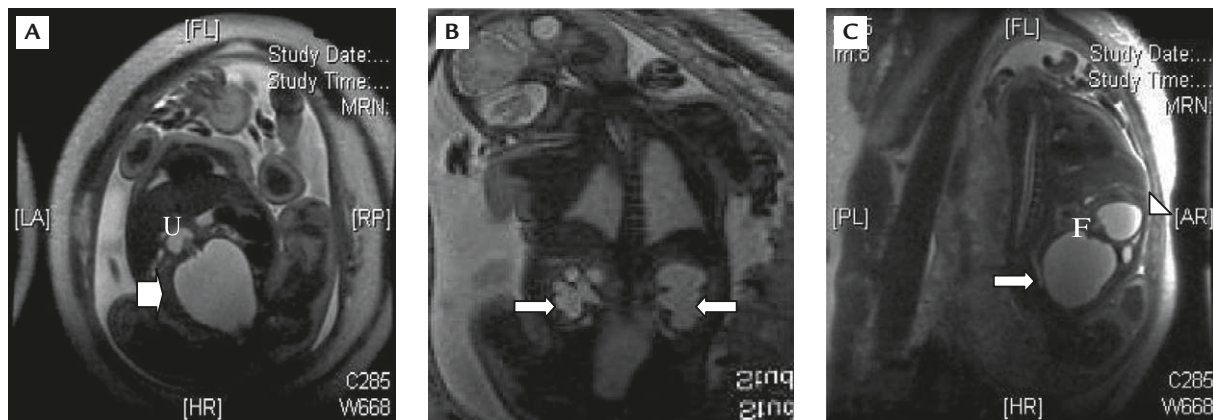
Fetal magnetic resonance imaging at 36 weeks of gestation. T2-weighted image in the coronal view showing: (A) fluid-filled mass (thick arrow) in the midline and connected to the dilated uterus (U); (B) marked bilateral hydronephrosis (arrows); and (C) T2-weighted image in the sagittal view showing the cystic mass (arrow) posterior to the bladder and a possible fistula (F) communicating with the bladder (arrowhead).
